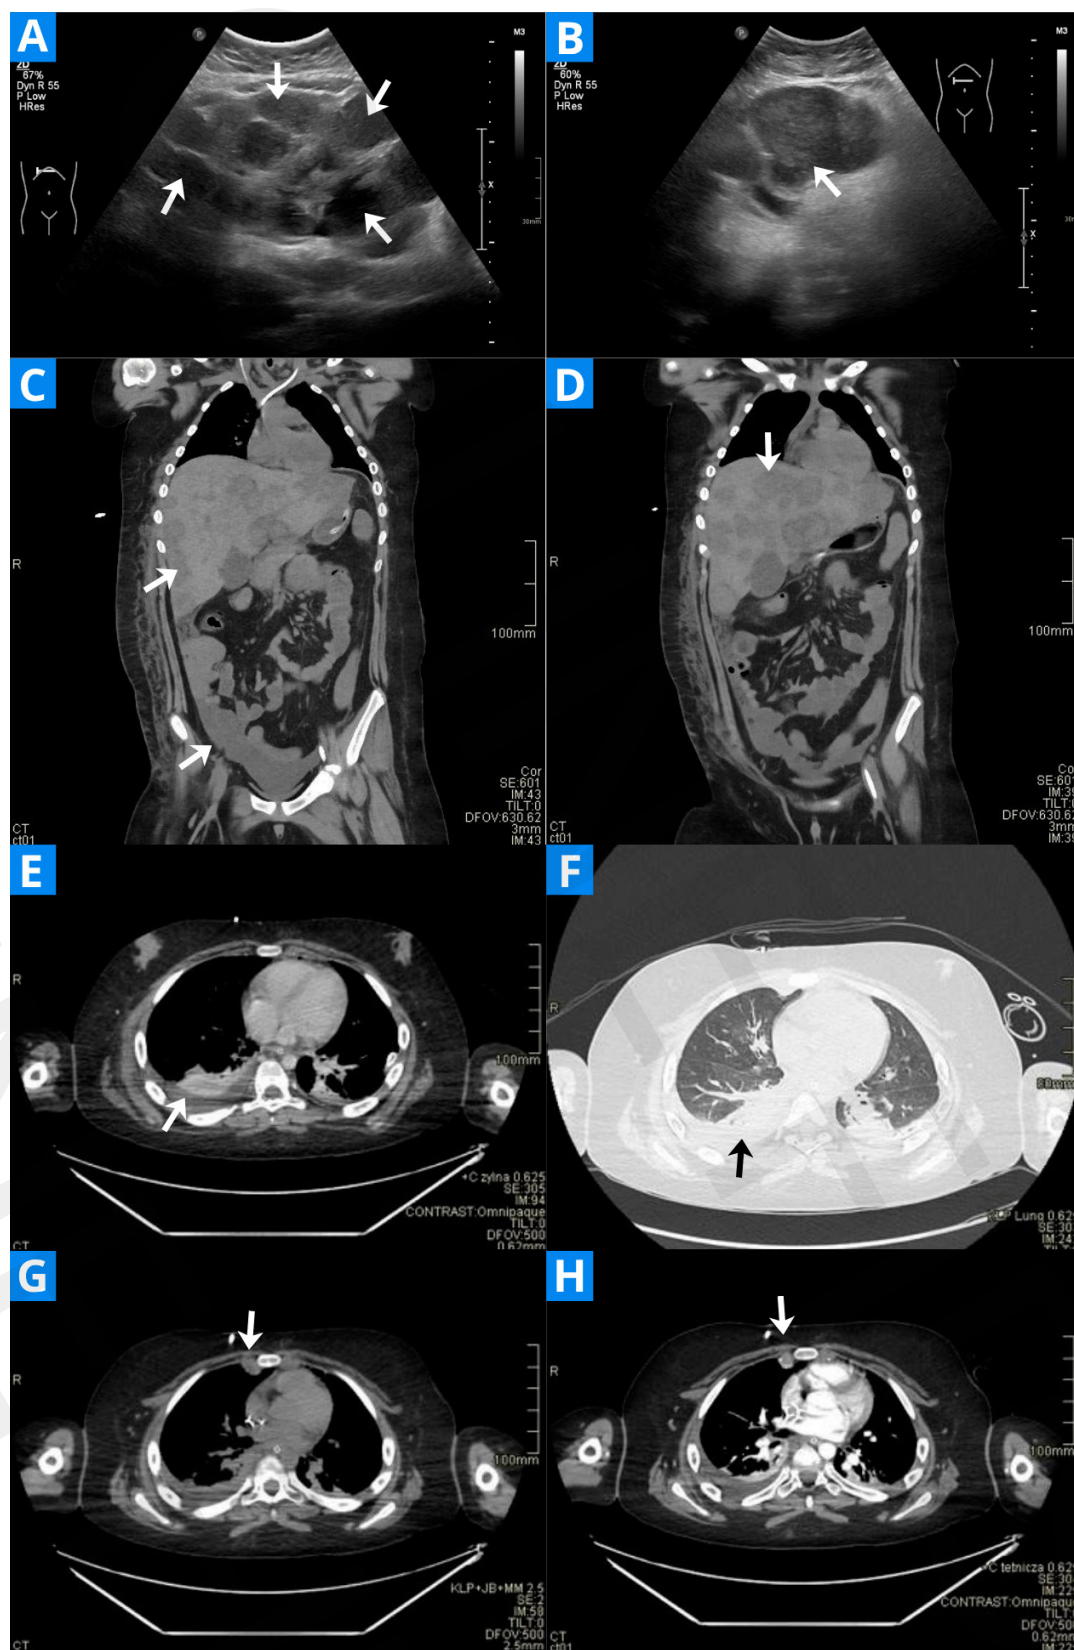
(A-H). Ultrasound examination revealed an enlarged, heterogeneous liver with numerous focal lesions occupying most of the liver parenchyma (A), the largest of which was located in the left lobe and measured approximately 65 mm in diameter (B). The remaining liver parenchyma showed increased echogenicity, indicating signs of steatosis. A CT scan revealed fatty tissue erosion in the right paracolic gutter area and subcutaneous tissue oedema covering the chest (C), as well as fluid in the abdominal cavity and pelvis and numerous metastatic lesions in the liver (D). A chest CT scan revealed numerous irregular areas of pulmonary parenchymal consolidation, most pronounced in the dorsal segments, especially in the right lung, and extensive, irregular areas of ground-glass opacity in both lungs. Fluid in the right pleural cavity with a thickness of up to 14 mm and in the interlobar fissure (E,F). An oval area measuring approximately 14x16x25 mm (APxRLxCC) is visible in the right paracardiac subpleural space, with an average density of approximately 16 HU, with marginal enhancement after administration of a meta-type contrast agent (G,H).
